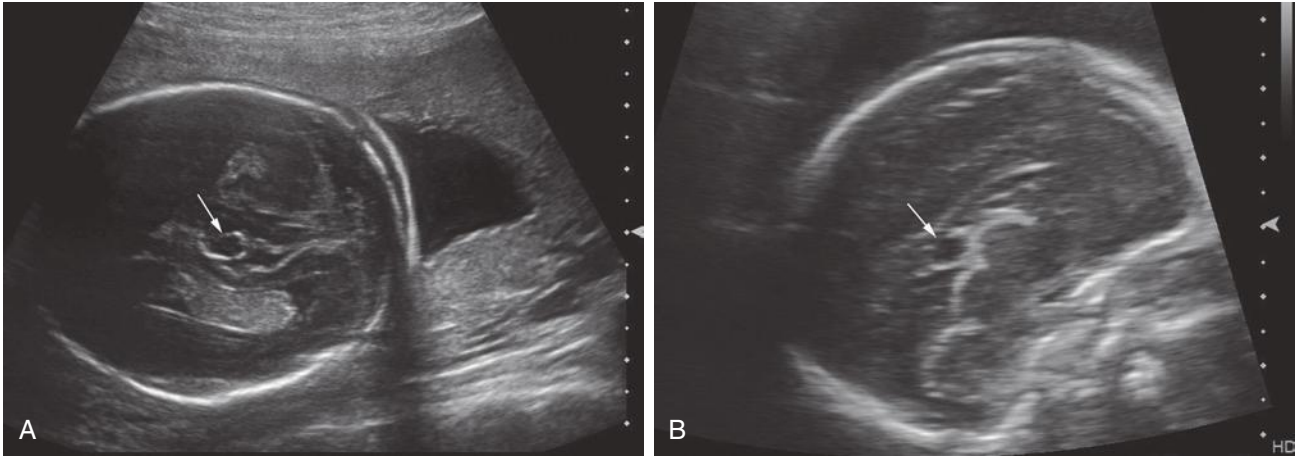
A, Cyst of the velum interpositum. A small midline cystic structure (*arrow*) is seen on this transverse axial sonogram. This finding may mimic a dilated third ventricle. B, On this sagittal view, the “cyst” (*arrow*) is located anteroinferior to the splenium of the corpus callosum, superior and posterior to the thalami. It is most often a benign finding. The differential diagnosis of a cyst of the velum interpositum would include dilated cavum vergae or arachnoid cyst of the quadrigeminal cistern.
